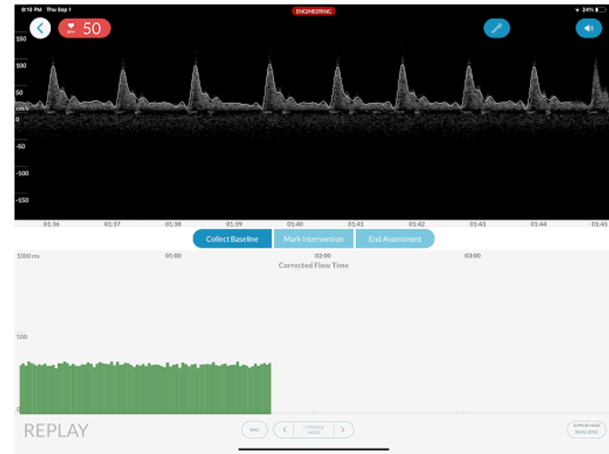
The wireless, wearable Doppler ultrasound system. (A) The device on the neck of a volunteer. (B) The graphical user interface of the ultrasound system displayed on an iOS device.
